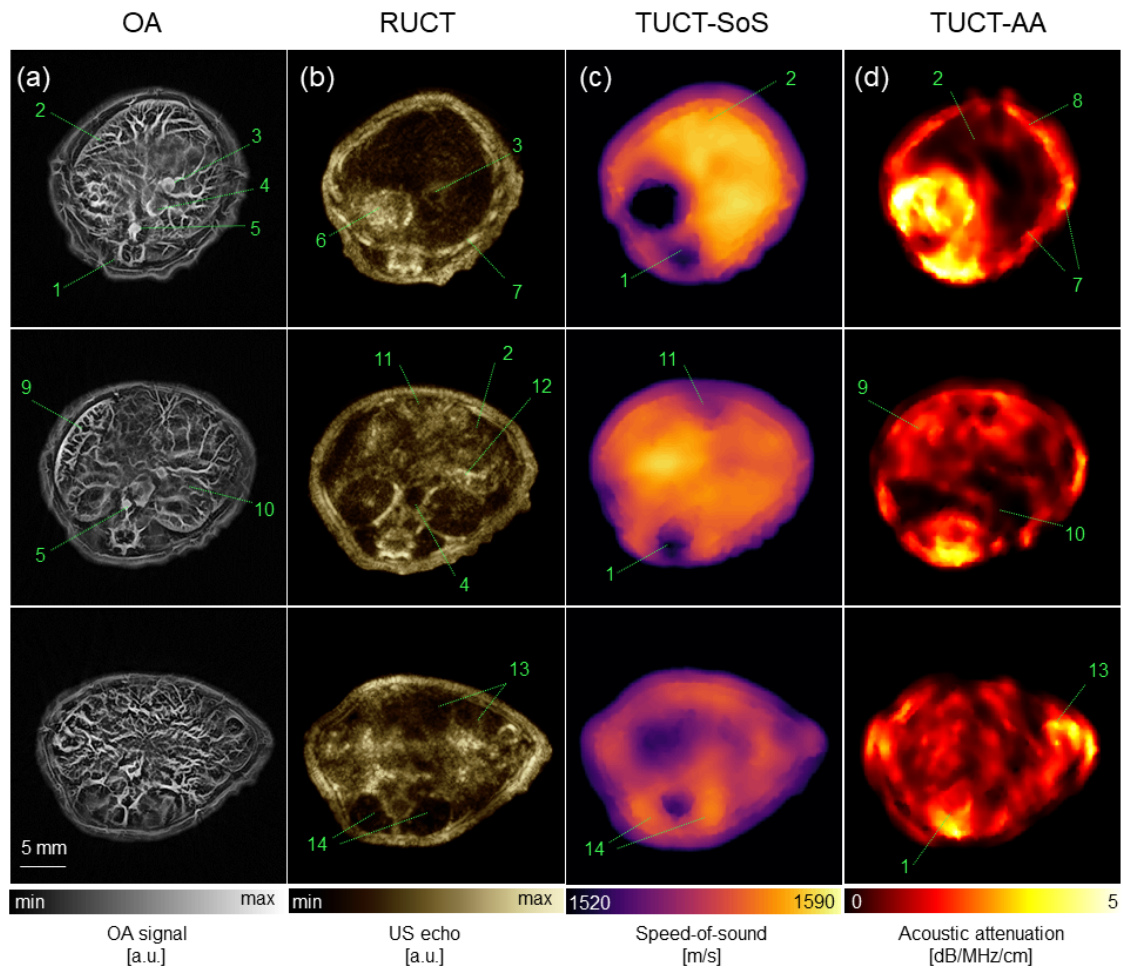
Hybrid transmission-reflection optoacoustic ultrasound (TROPUS) whole-body imaging. (a) Representative cross-sections acquired in the optoacoustic mode; (b) The corresponding reflection-mode ultrasound images; (c), (d) The corresponding transmission-mode ultrasound images showing the distribution of the speed of sound and acoustic attenuation, respectively. Annotations: 1: spinal cord; 2: liver; 3: vena porta; 4: vena cava; 5: aorta; 6: stomach; 7: ribs; 8: skin/fat layer; 9: spleen; 10: right kidney; 11: cecum; 12: pancreas; 13: intestines; 14: muscle.
